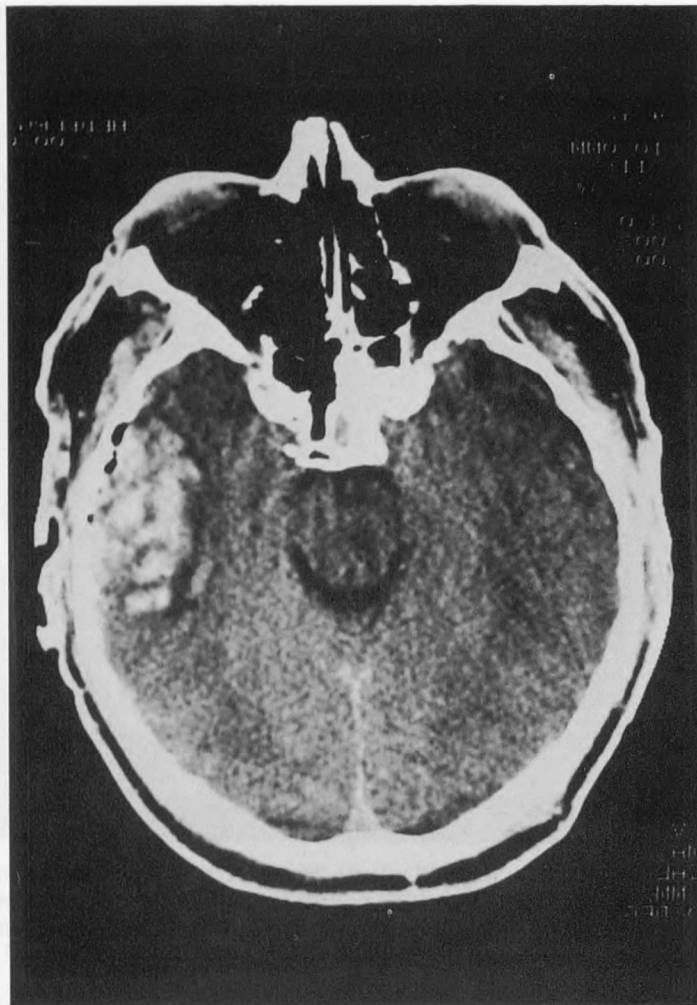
CT scan showing right temporal lobe contusions. These contusions tend to enlarge and lead to brain swelling.
